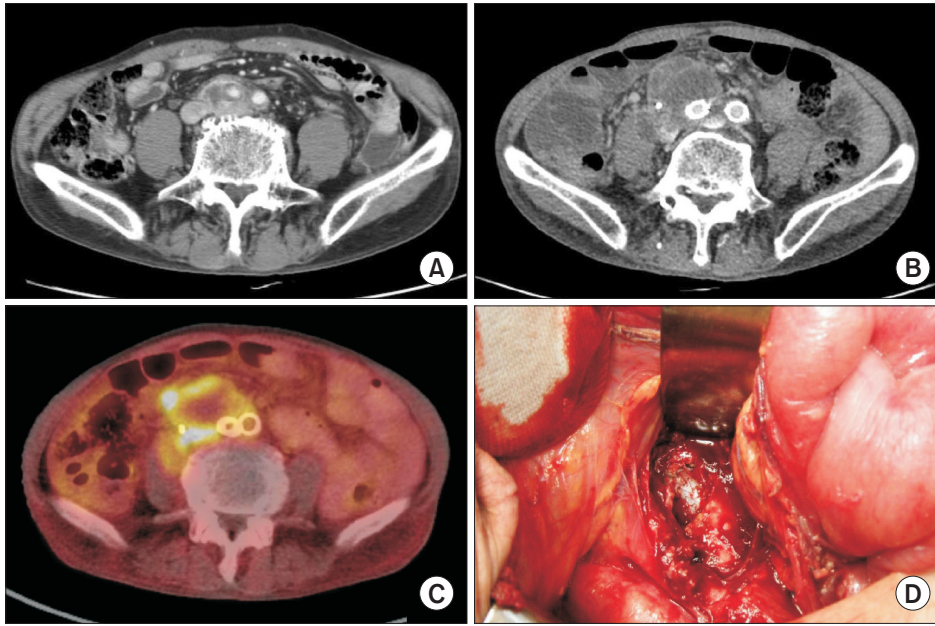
Serial images of an infected stent-graft. (A) Computed tomography (CT) image before endovascular aneurysm repair (EVAR); (B) CT image after EVAR; (C) positron emission tomography-CT image after EVAR showing hot uptake around the stent-graft compatible with infection; (D) operative finding of the infected stent-graft with gross pus discharge.
